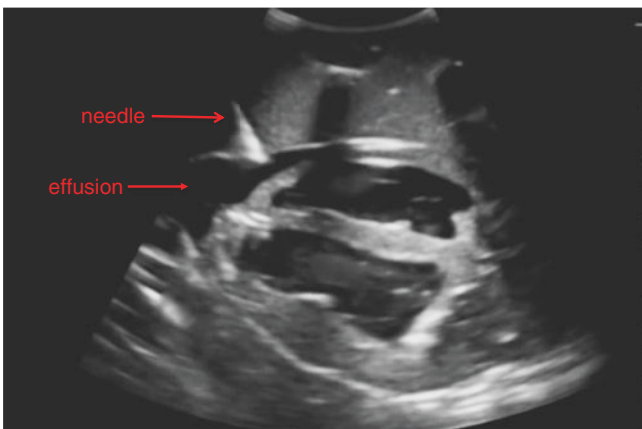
Ultrasound view demonstrating the needle as it enters the effusion in real time. The arrow shows the tip of the needle entering the effusion
